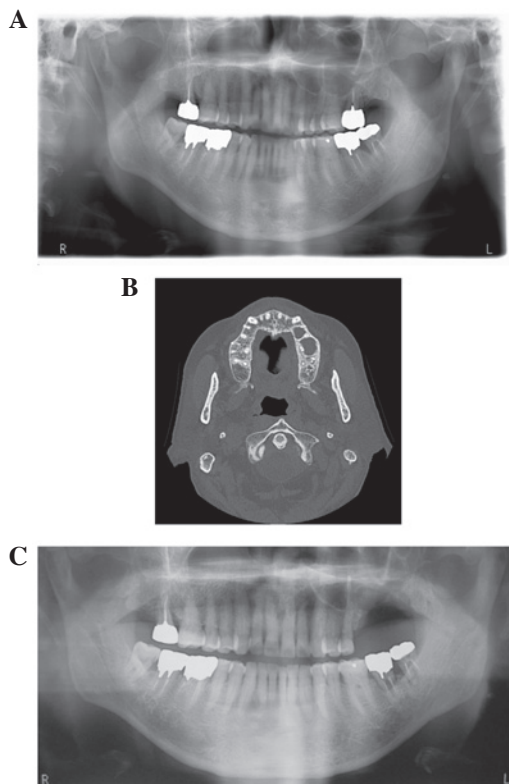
Imaging findings for case 2. (A) Pre-operative panoramic radiographs show sites of bone resorption in the left maxilla. (B) Pre-operative computed tomography shows bone sclerosis and sequestrum formation in the left maxilla. (C) Post-operative panoramic radiographs show the resected portion from the left maxilla.
